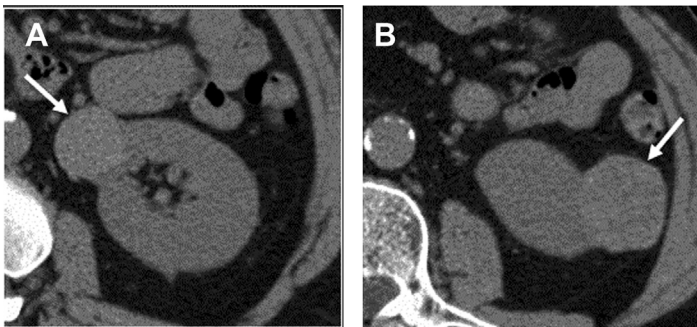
Unenhanced axial CT images from a 57-year-old woman with 2 left renal masses. (A) Hyperdense cyst is homogeneous and measures 72 HU (arrow). (B) pRCC is mildly heterogeneous, has angular margins, and measures 58 HU (arrow).
